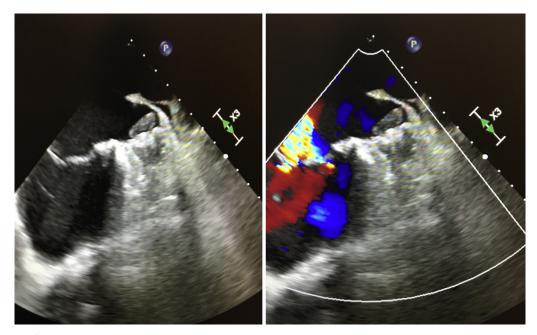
Transesophageal echocardiogram showing a thrombus on the atrial surface of WATCHMAN device.
